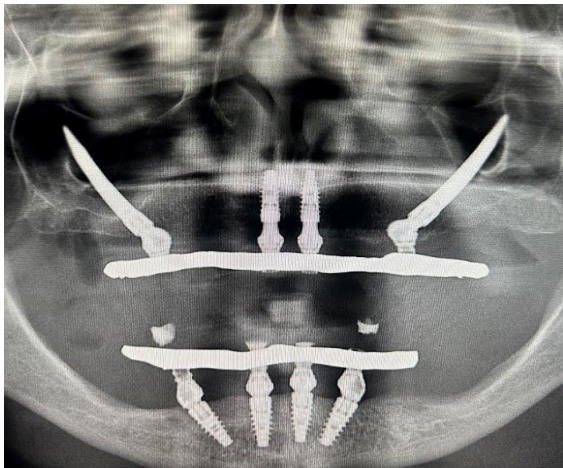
2-Year Post-operative Orthopantomography
